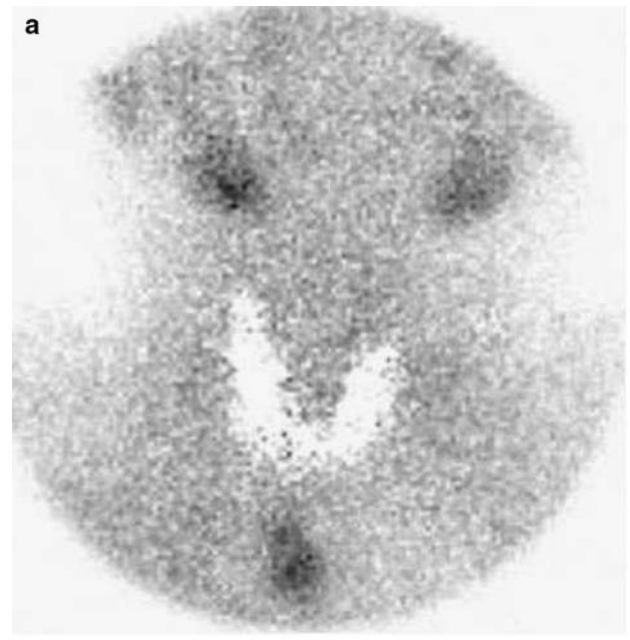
(a) ^{99m}Tc -sestamibi scintigraphy (subtraction protocol): right parathyroid adenoma probably along thyrothymic ligament. (b) ^{99m}Tc -sestamibi scintigraphy (SPECT images, profile): same right inferior parathyroid adenoma along the thyrothymic ligament: position 3 (arrow)
